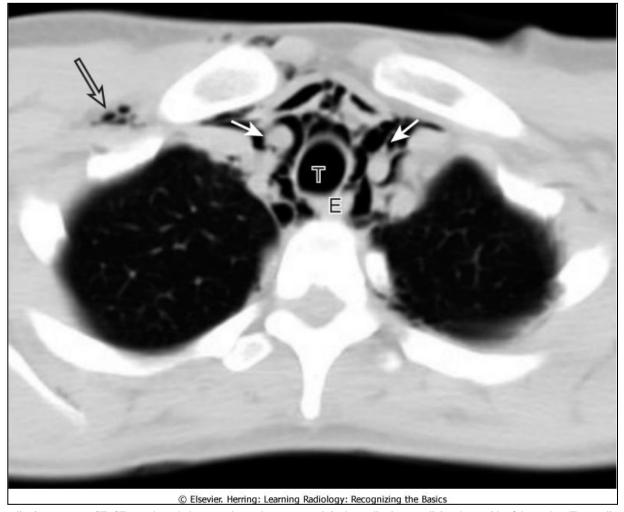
Pneumomediastinum seen on CT. CT scan through the upper thorax demonstrates air in the mediastinum outlining the outside of the trachea (T) as well as the esophagus (E) and the major vessels leading to the neck (closed white arrows). There is a small amount of subcutaneous emphysema (open black arrow).
